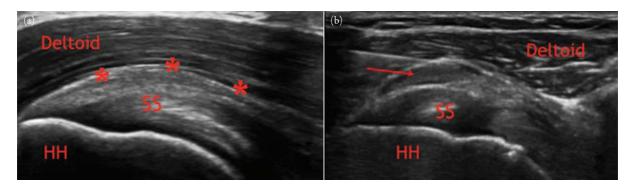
Subacromial bursitis. Panel (a) shows a grayscale sonographic image in longitudinal plane of the shoulder showing the expected location of the subacromial-subdeltoid (SA-SD) bursa. The SA-SD bursa (*) is a potential space deep to the deltoid muscle and superficial to the supraspinatous (SS) tendon on this image. The supraspinatous tendon is inserting on the humeral head (HH). In Panel (b), a grayscale longitudinal ultrasound images shows a linear hyperechoic needle tip (originating from the left) in the expected region of the SA-SD bursa during ultrasound guided bursa injection. The bursa (arrow) is distended prior to injection consistent with bursitis in this patient with signs and symptoms of external impingement.
